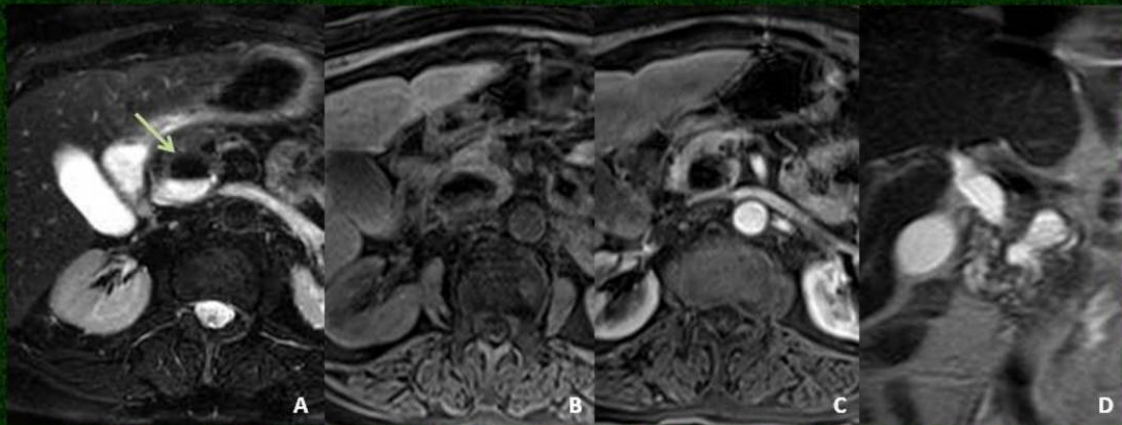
Extramural diverticulum on MRI. Axial T2-weighted (A), T1-weighted fat-suppressed before (B) and after Gadolinium administration (C) and coronal HASTE (D) images show a round heterogeneous lesion with an air-fluid level (arrow in A) and a thin enhancing wall projecting in the uncinate process of the pancreatic gland and communicating with the second portion of the duodenum.
